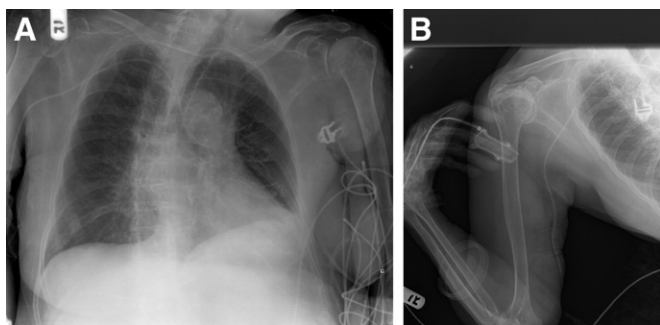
X-ray confirmation of successful central line placement via axillary approach.
